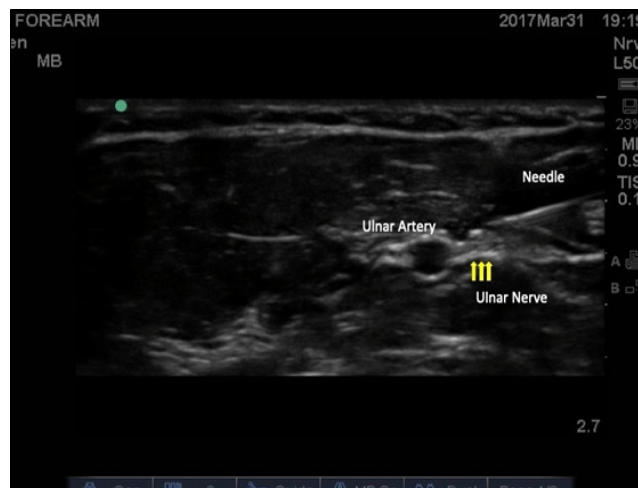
Image shows the ulnar nerve block performed under ultrasound guidance in the forearm.
